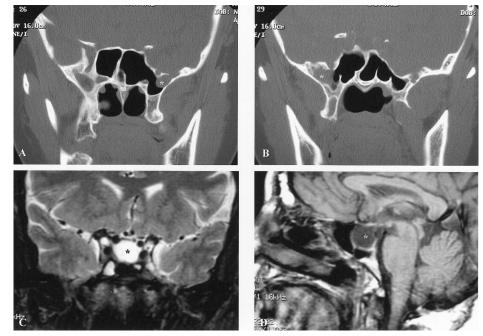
Coronal CT scans demonstrating a left-sided sphenoid lateral recess encephalocele (A) that is being observed and a right-sided sphenoid lateral recess encephalocele (B) after endoscopic transpterygoid repair. Neo-osteogenesis and residual soft tissue fibrosis after obliteration of the right-sided lateral recess are evident. Coronal (C) and sagittal (D) MRI scans of the same patient demonstrate the empty sella (*). The sella turcica is filled with cerebrospinal fluid, and the residual pituitary gland is compressed.
